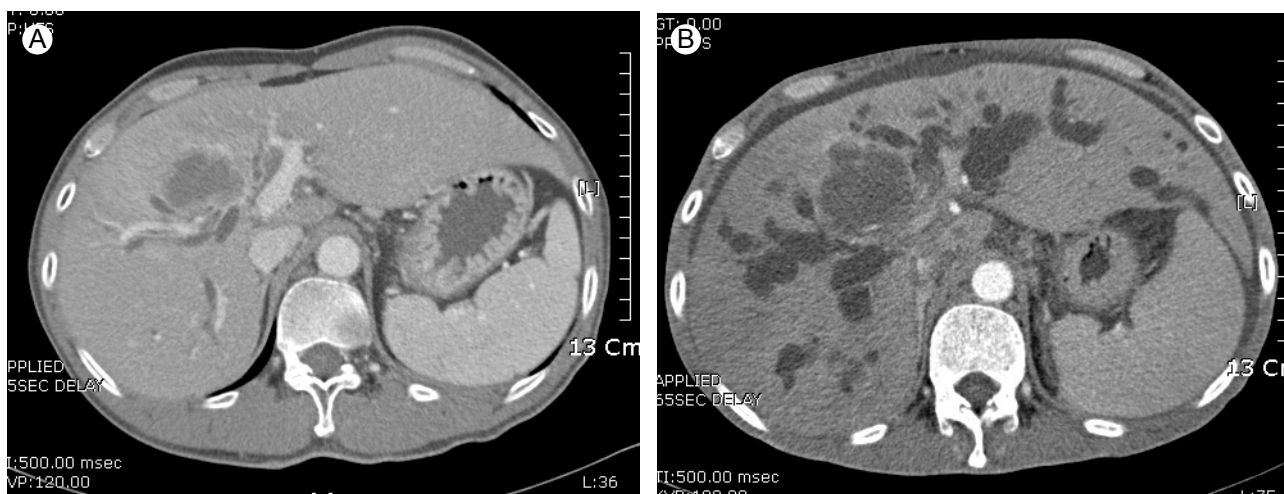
Abdominal computed tomography (CT) scans with contrast. (A) The initial CT scan revealed a mass with slightly dilated intrahepatic bile ducts in the right lobe of the liver. (B) Follow-up CT showed an increased size of the mass along with severe intrahepatic ductal dilatation.
